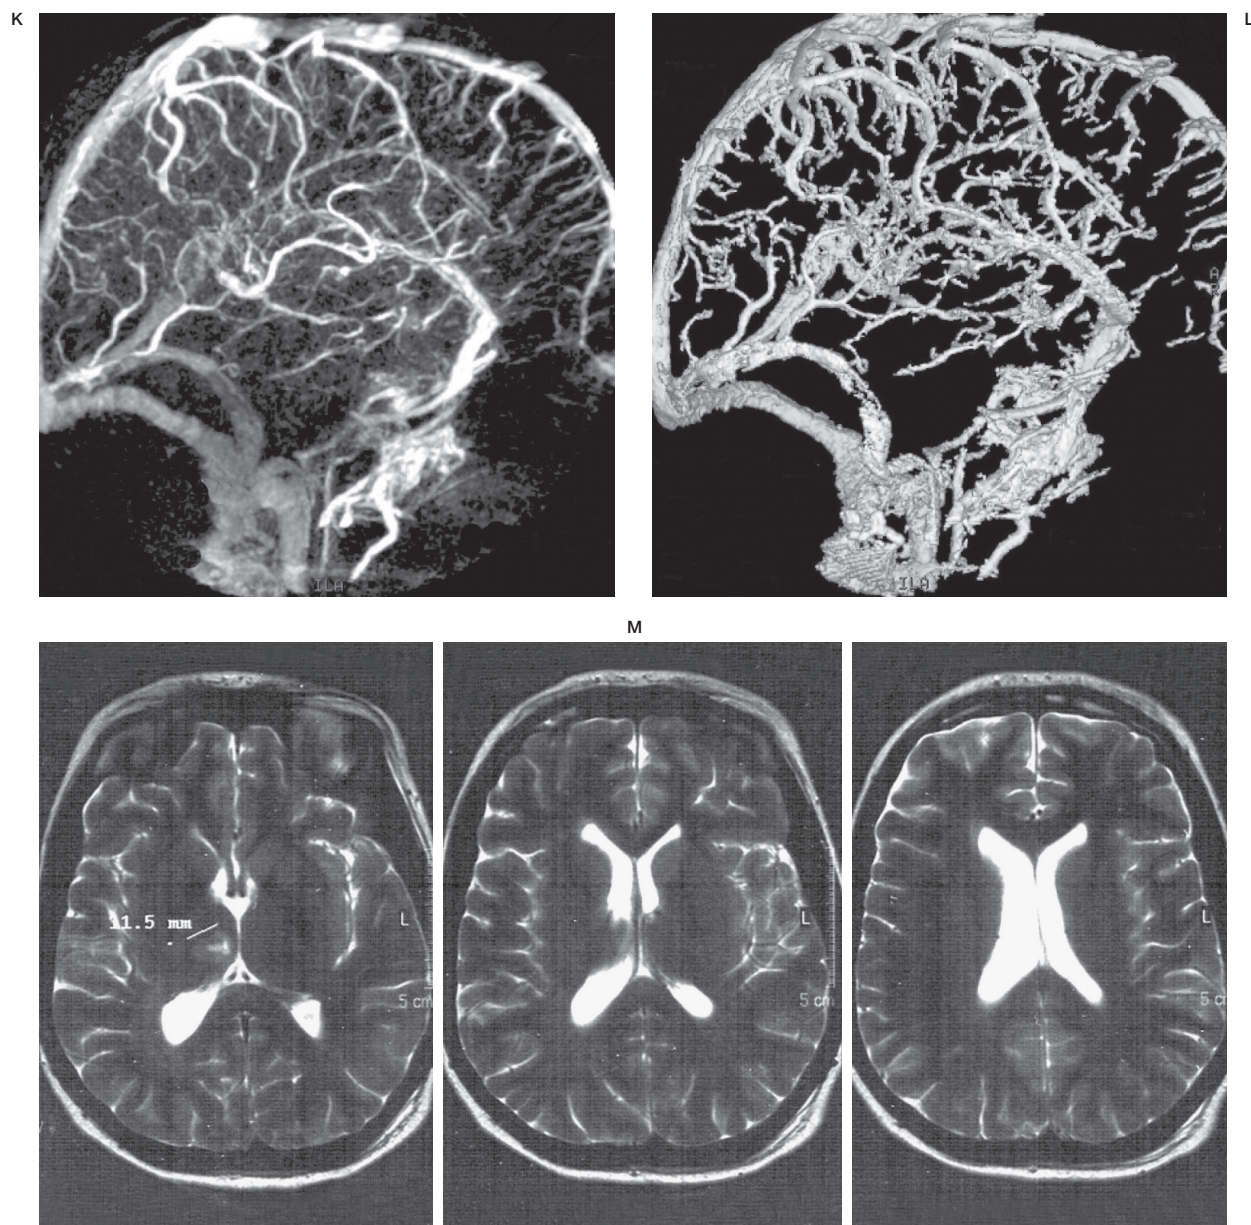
Interventional procedure + 3D-Xra control angiography and MRI after thrombolysis G) Anteroposterior DSA (day 5) – right transverse sinus and sigmoid sinus thrombosis H) 3D-Xra rotational angiography, remaining thrombosis of the straight sinus, vein of Galen and basal vein of Rosenthal. Right transverse and sigmoid sinus occlusion. I) 4F-Vertebral Tempo Cordis JJ catheter introduced into the right transverse sinus near the Torcular, through the fresh thrombus for local thrombolysis. J) Anteroposterior DSA (day 7) – 48 hours of thrombolysis - recanalisation of the right transverse and sigmoid sinus. K,L) 3D-Xra angiography with complete good straight sinus, vein of Galen, basal vein of Rosenthal and internal cerebral vein opacification. M) Follow-up MRI after one month with remaining small ischemia in the right thalamic area.
